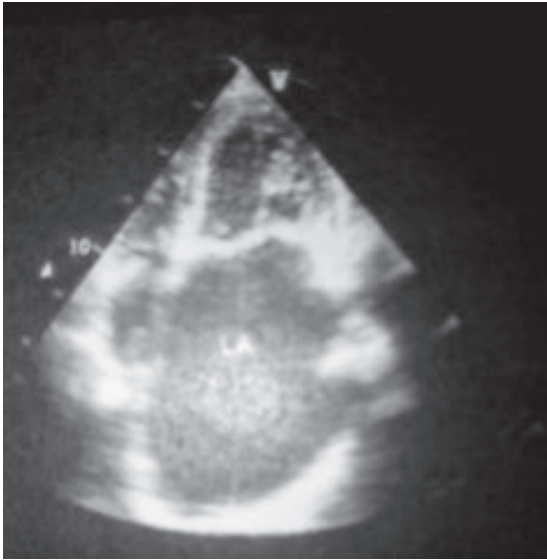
Pre-operative echocardiogram showing giant left atrium
